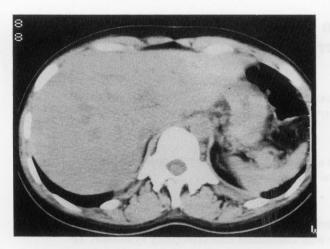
Radiograph CT shows a small spleen.
